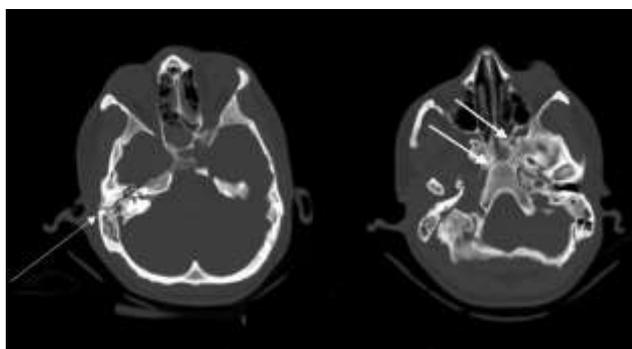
CT scan of 35-year-old male with recent motor vehicle accident demonstrating longitudinal fracture of the right petrous bone (thin arrow) that extends into the skull base (thick arrow)
